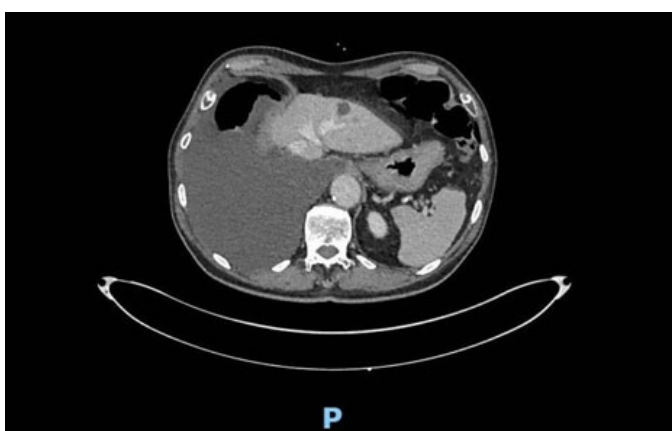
Showing CT scan with large right effusion but no pleural nodules or thickening 178 × 117 mm (120 × 120 DPI).
